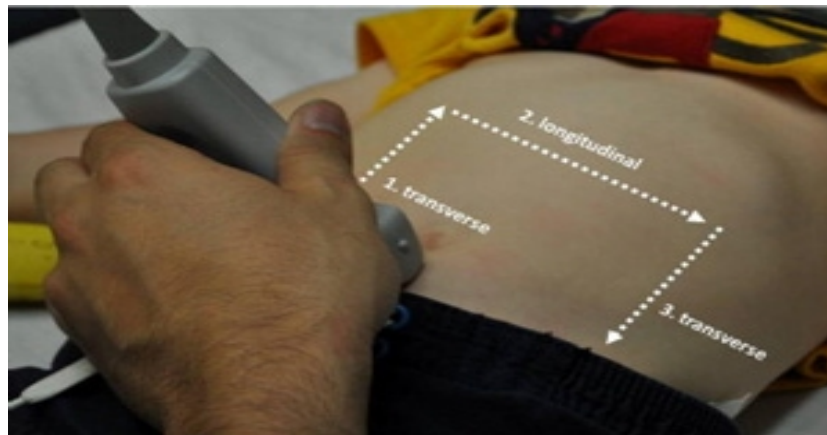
How to do abdominal ultrasound for intussusceptions
